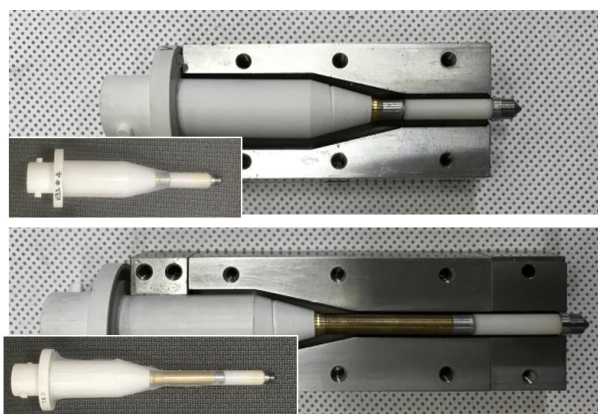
Design modification of the miniature X-ray tube and the applicator to apply dwell positions
